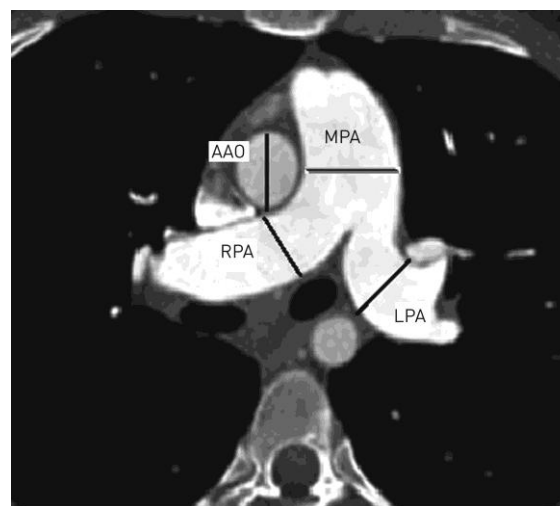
Computerized tomography (CT) for Pulmonary Hypertension (19)
